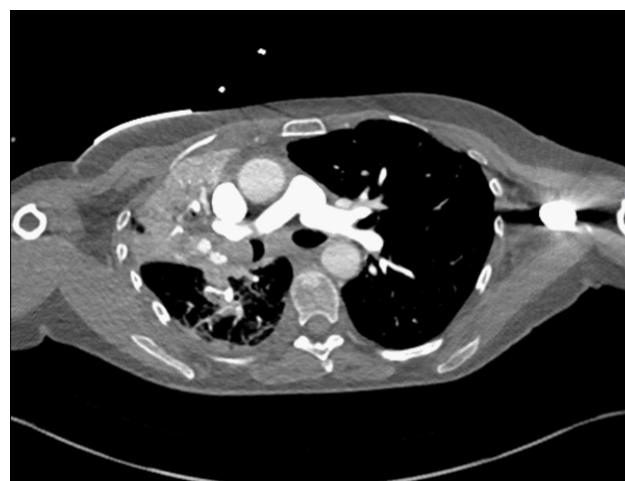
CT imaging revealing collapse of the right upper and middle lobes, with partial collapse of the right lower lobe. This is attributed to a high-density, convex-margin lesion in the right main bronchus, suspicious for an obstructive endobronchial process.
